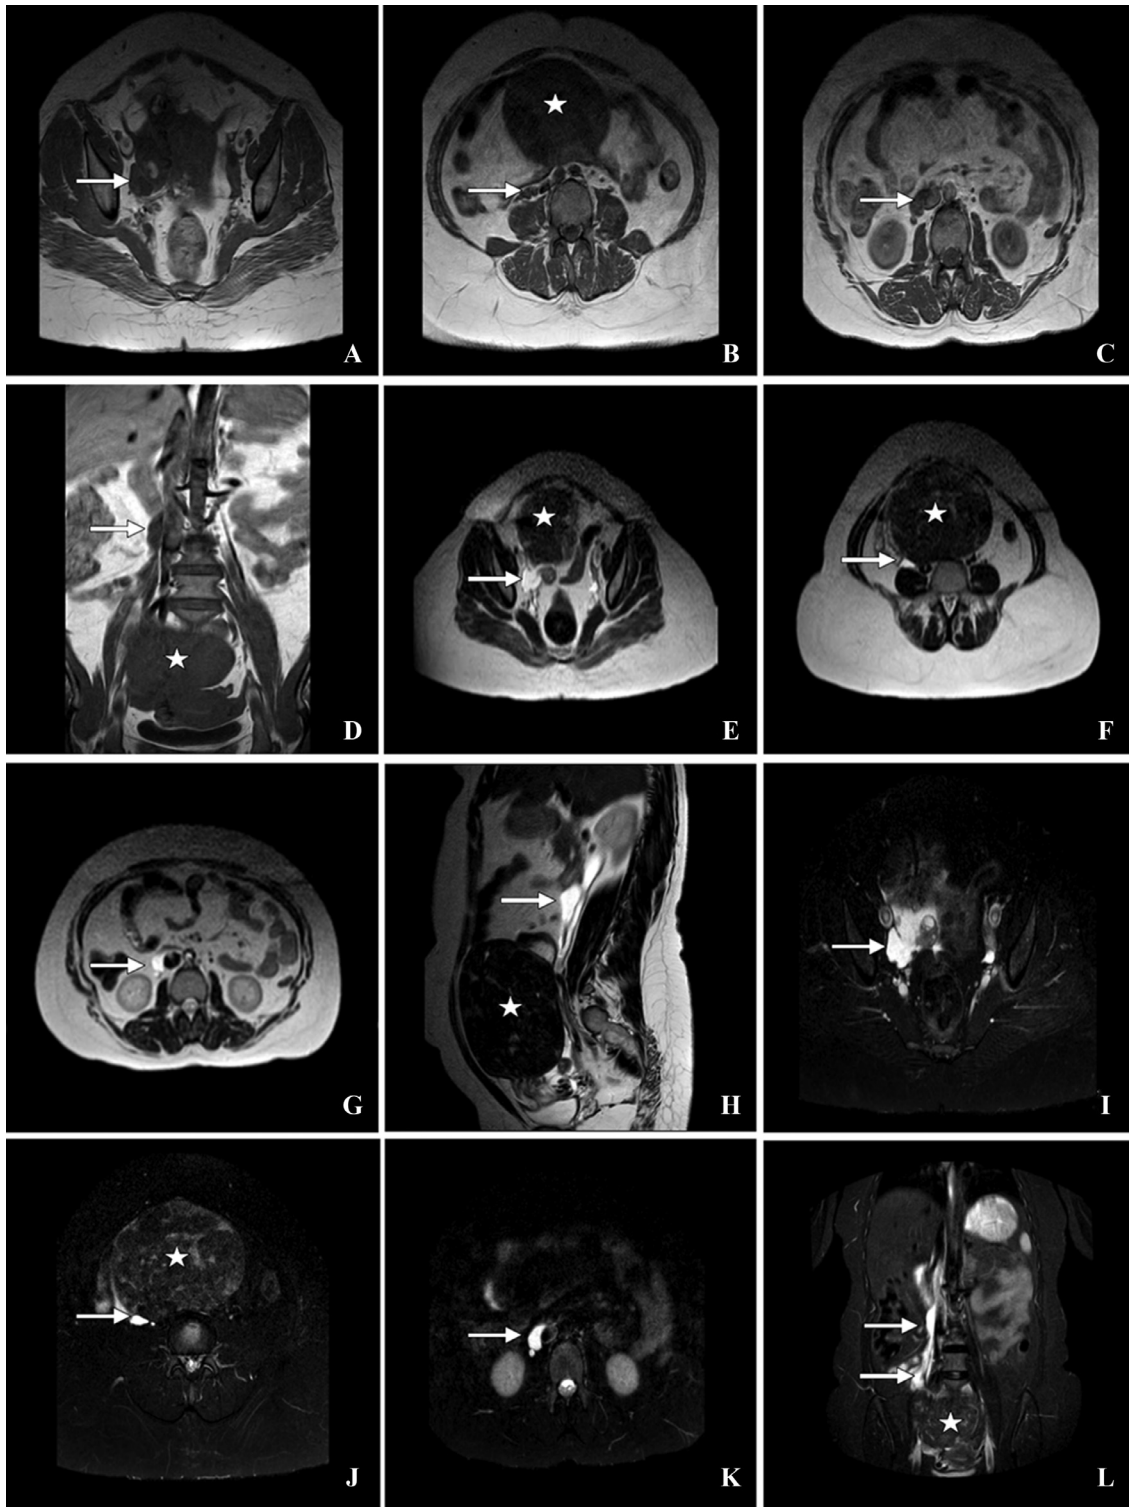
(A-L): A 40-year-old woman complained of lower abdominal pain, distension, and bloating that had been worse during the previous 6 months. Magnetic Resonance Imaging (MRI)—Abdomen: (A, B, C) T1W Axial, (D) T1W Coronal, (E, F, G) T2 Axial, (H) T2 Sagittal, (I, J, K) SPIR Axial, (L) SPIR Coronal shows a bulky uterus with T1W: focal isointense (iso to myometrium) and T2W: heterogenous hypointense-hyperintense mass lesion in the antero-superior wall uterus (fundus) (SPIR: heterogeneous hypointense-hyperintense)—Sub-serosal fibroid with necrotic degeneration (white asterisk). T1W: A focal multiloculated hypointense, and T2W: hyperintense cystic lesion in the right adnexa (epicenter in the ovary) of serpiginous appearance extending superiorly along the para-caval region till the infra-renal segment of the pre-caval region (SPIR: hyperintense)—Ovarian lymphangioma (short white arrows).
